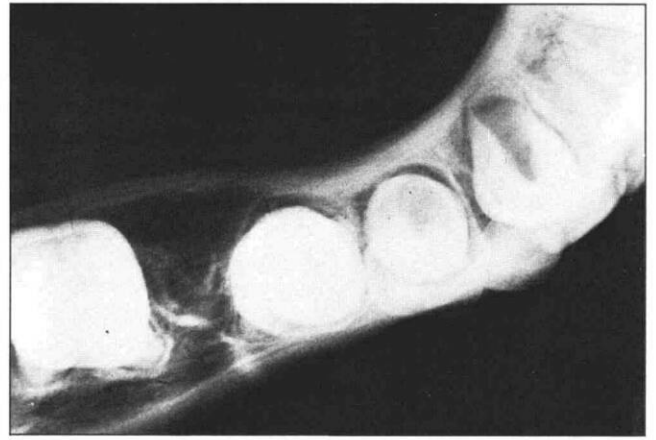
Occlusal radiograph on the left mandible showing lingual orientation of the lesion with no apparent cortical erosion.
